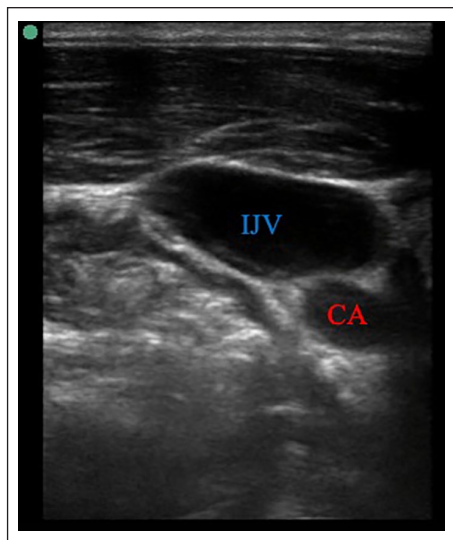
Ultrasound image of the right internal jugular vein in a prone COVID-19 patient.
